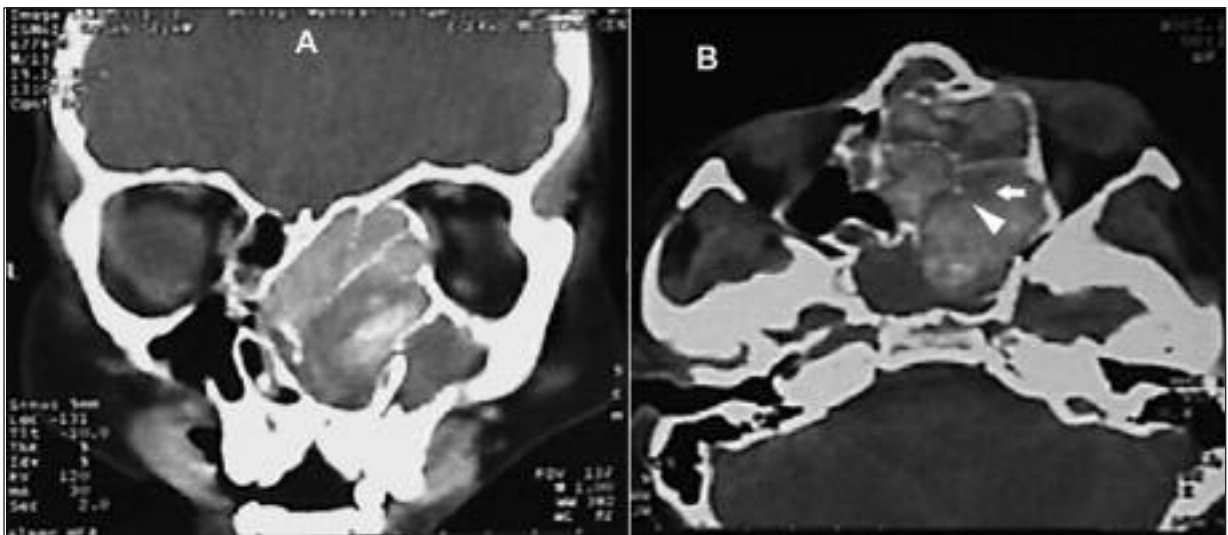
(A) Coronal CT shows complete erosion of bony septates of the anterior and posterior ethmoid cells. (B) Axial CT of the paranasal sinuses shows point erosion of anterior bony wall of the right sphenoid sinus.
